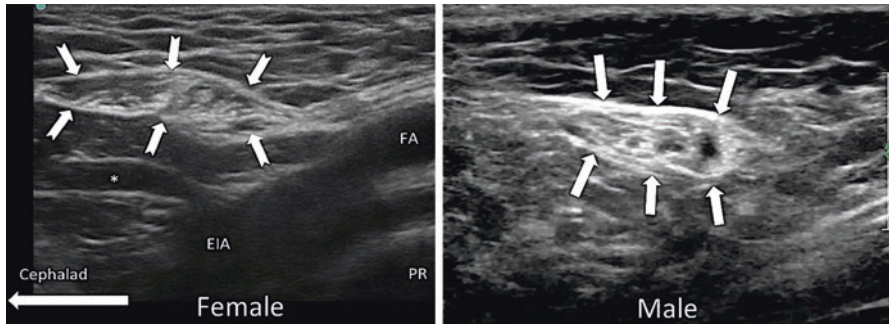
Sonography of inguinal canal for female (left) and male (right). EIA external iliac artery, FA femoral artery, PR pubic ramus, * inferior epigastric artery. (Reprinted with permission from Philip Peng Educational Series)
